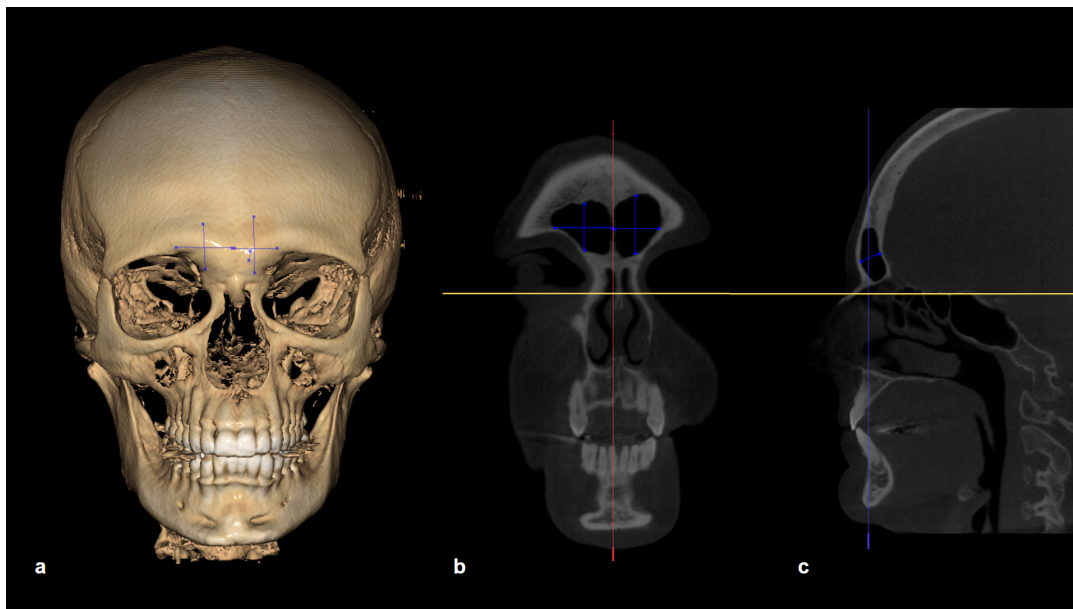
a. 3D reconstructed skull showing linear measurements of a frontal sinus. b. CBCT measurements in the coronal plane. c. CBCT measurements in the sagittal plane. Source: Own elaboration.
